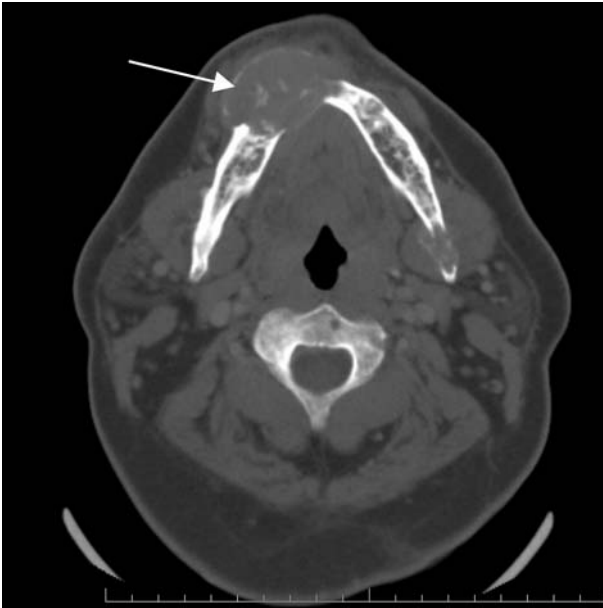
CT scan of the jaw shows multiple tumours with a remarkably large tumour in the right mandible.
